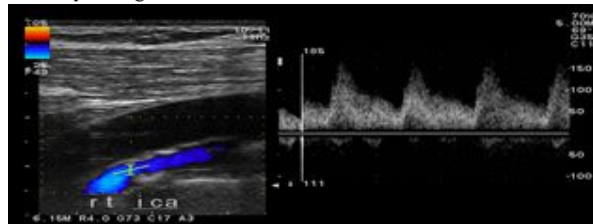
longitudinal colour doppler image raised PSV at the level of stenosis about %cms/sec corresponding to moderate degree of stenosis. On DSA not shown this pt was confirmed as stenosis of 60%.
